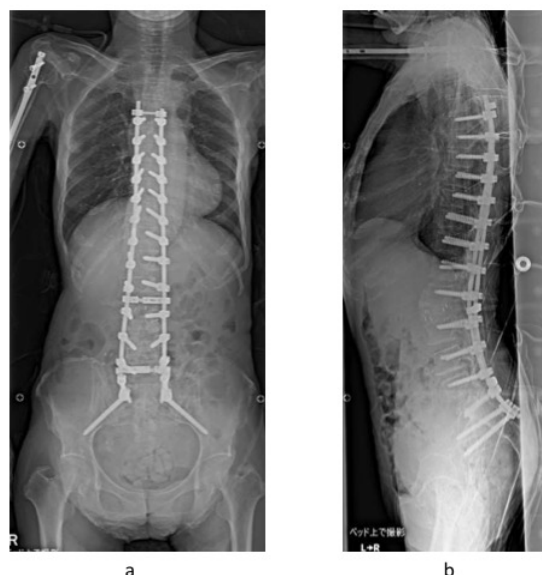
Postoperative X-ray in supine position. (a) Anterior-posterior radiograph. Corrective spinal surgery with resection of L2 and instrumentation from T4 to pelvis was performed. Good coronal alignment is achieved. (b) Lateral radiograph. Proper lumbar lordosis is achieved.
